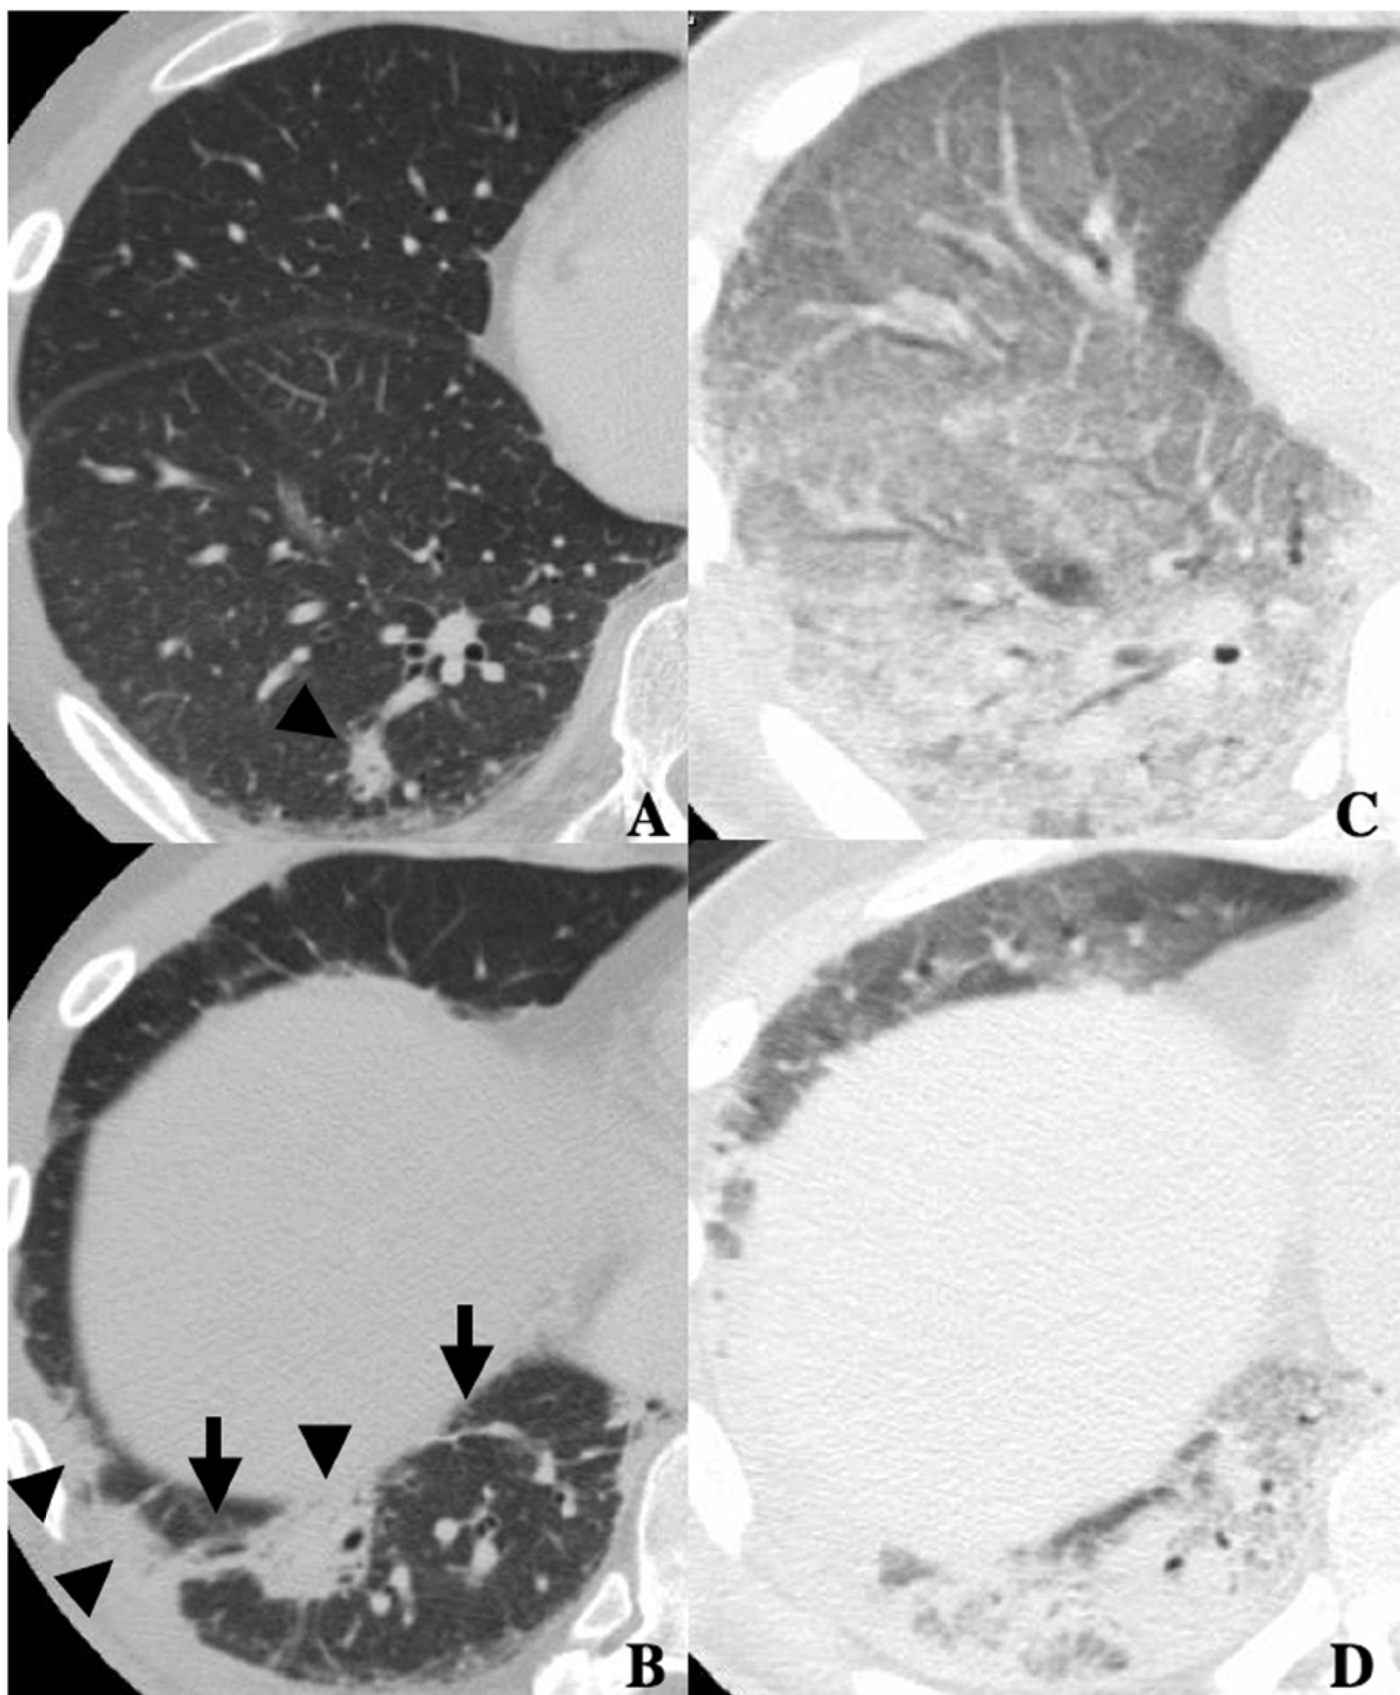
High resolution computed tomography (HRCT) images showing lower consolidation/ ground-glass attenuation (GGA) pattern in a 44-year-old man positive for anti-CADM-140 antibody (anti-CADM-140). A and B: At diagnosis, peripheral and peribronchovascular consolidations were observed (arrowheads). Interlobular septal thickening and nonseptal linear or plate-like opacities were also seen (arrows). C and D: Despite treatment for 6 weeks, severe respiratory failure developed, requiring mechanical ventilation. Diffuse GGA and consolidation with air bronchograms were extended in the whole lungs. Surveillance at this point revealed no evidence of infection. The patient died of respiratory failure 1 week later.
